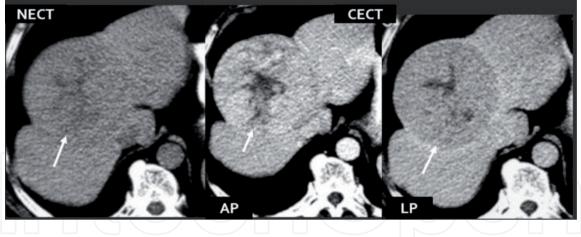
CT evaluation: liver adenoma with central necrotic area and encapsulation (arrow).*
